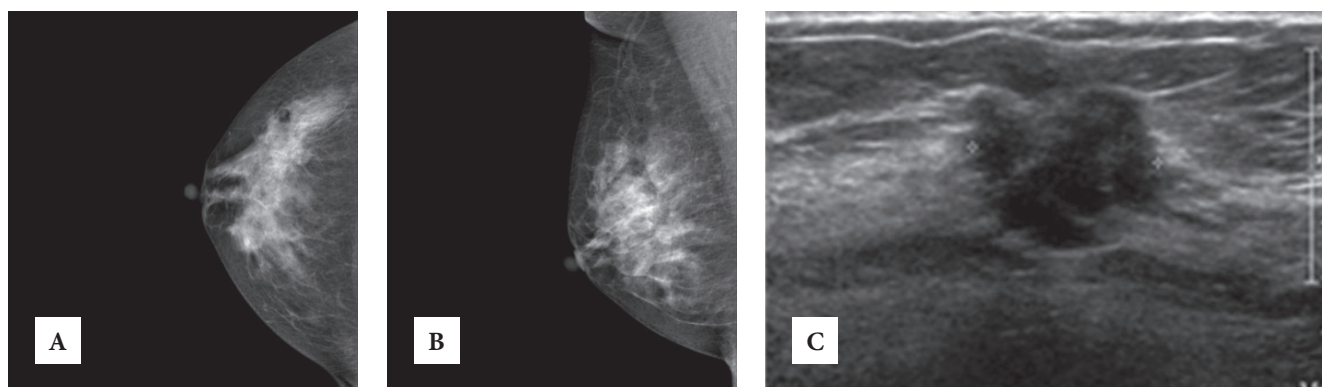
Mammographic and Ultrasonographic finding of breast. (A),(B) : There is a 2.0 cm spiculated isodense nodule at right mid outer portion. (C): There is a 1.7×2.0 cm spiculated low echoic nodule with invasion to retro mammary fat at 2 cm from right nipple.
